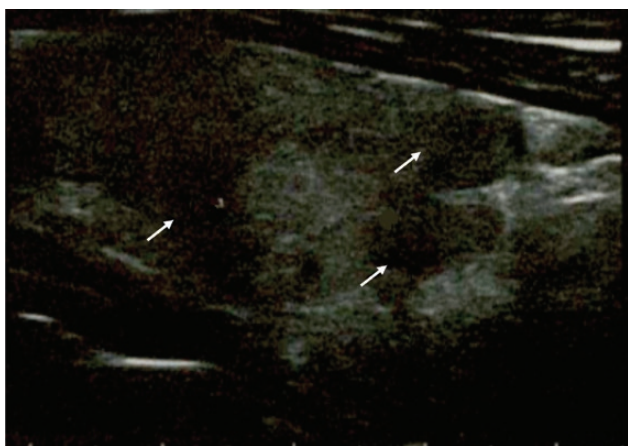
Thyroid ultrasound performed during the thyrotoxic phase, showing multiple hypoechoic areas (arrows).
